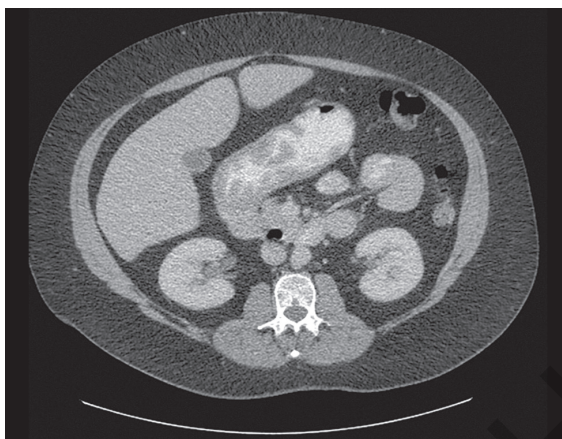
Duodenal involvement with nodular appearance on CT.
